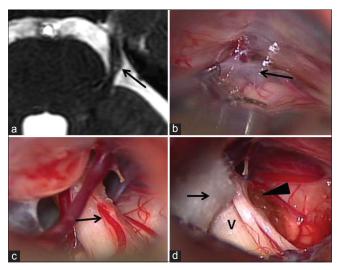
Case 7 (a) axial three-dimensional fast imaging with steadystate acquisition magnetic resonance imaging showing deformation of the left trigeminal nerve root (arrow), (b) intraoperative photograph. The arachnoid membrane is thick (arrow) around veins, arteries, and nerves, (c) intraoperative photograph. A left superior cerebellar artery branch passing between the motor and sensory component of the 5th cranial nerve (arrow), (d) intraoperative photograph. A left superior cerebellar artery branch is transpositioned distally and fixed to the dura mater of the suprameatal tubercle using a Teflon sling (arrow), a Teflon ball (arrowhead), and fibrin glue
